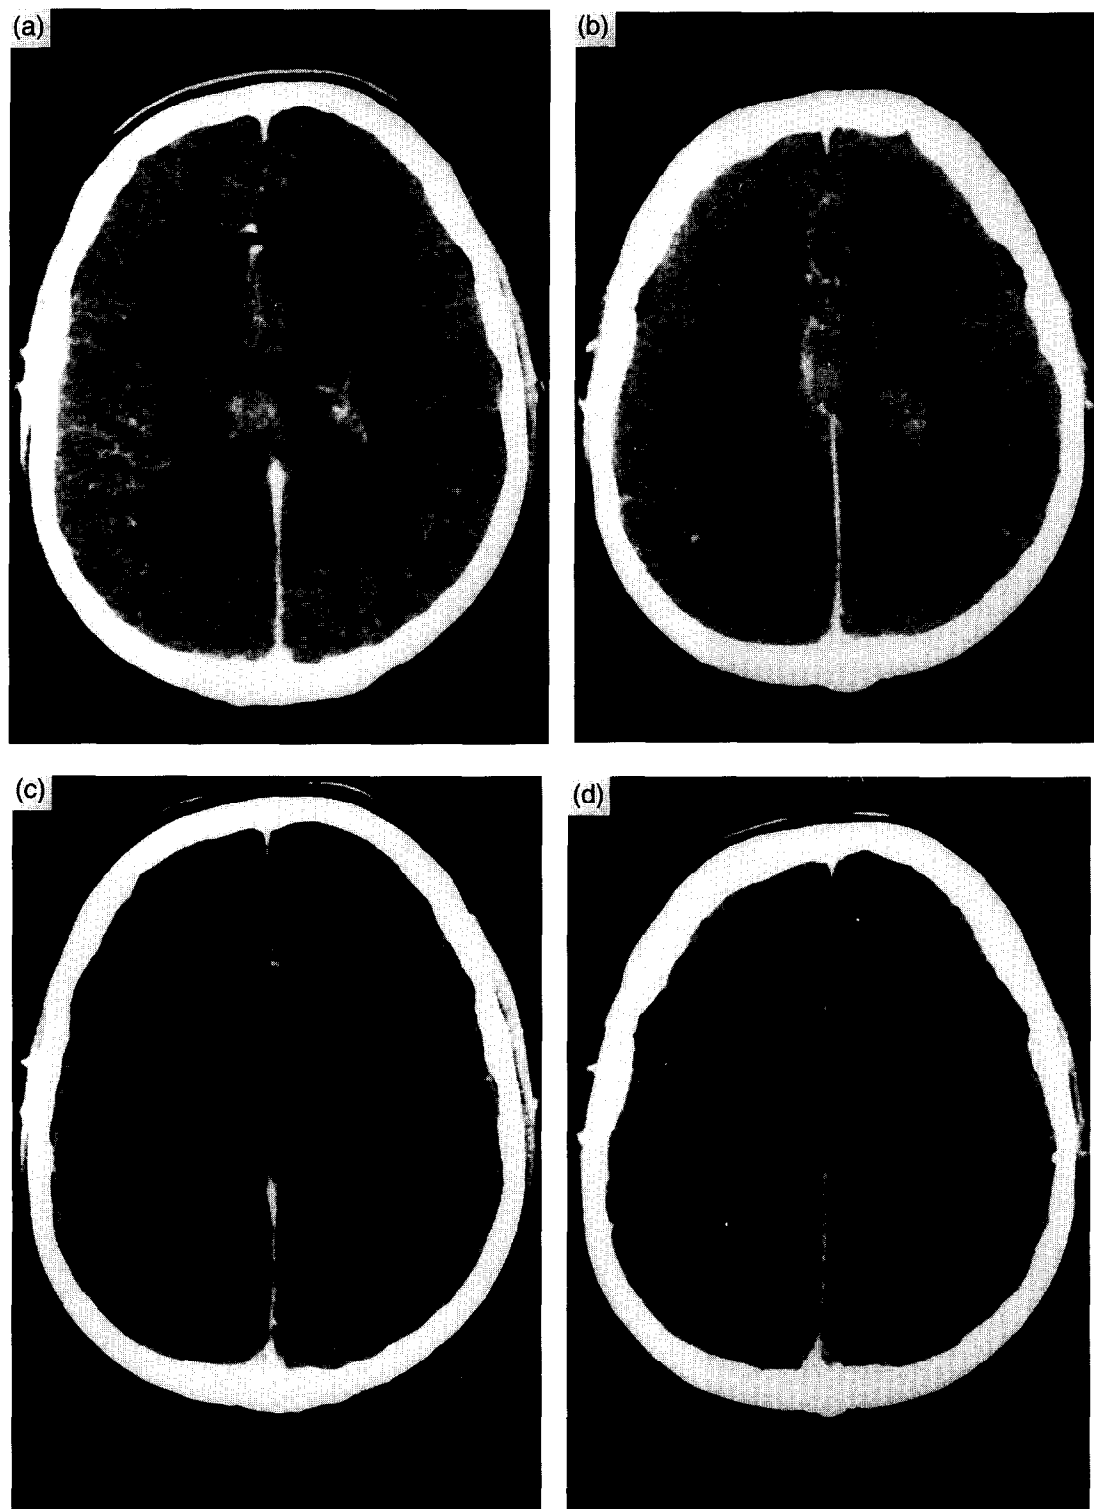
(a) and (b) CT scan of a patient with an anaplastic glioma at recurrence; (c) and (d) a partial response was observed after 3 months and was maximum after 6 months.
